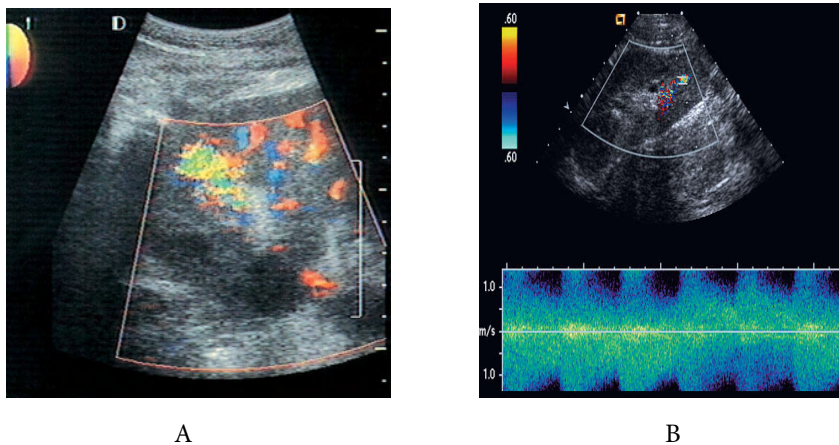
(A) Arteriovenous fistula. Color flow Doppler image demonstrating a focal increase in intrarenal flow, with a colored tissue murmur outside the renal vessels caused by vibration of the adjacent renal parenchyma. (B) Spectral Doppler tracing obtained at the site of the fistula, showing reveals a high-velocity, turbulent arterial tracing.
